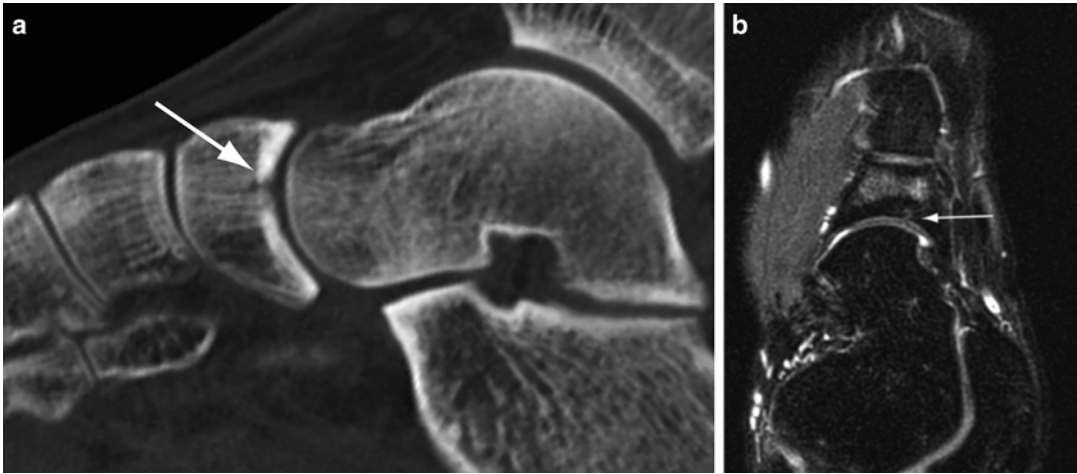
Cortical resorption cavity. (a) Sagittal multiplanar CT image of the foot shows focal osteopenia in the cortex at the point of the fracture (arrow) indicating a
